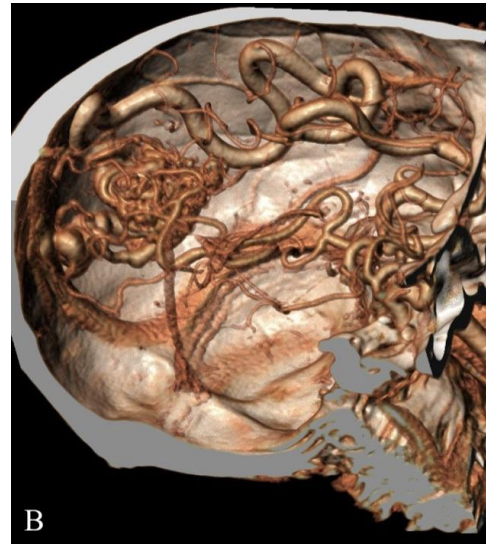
Head CT scan demonstrating intraparenchymal hemorrhage in the left parieto-occipital lobes with intraventricular bleeding in the ipsilateral lateral ventricle (a-b); the presence on multiple small calcifications and dilated vessels already raises the strong suspicion of the presence of a bAVM. CTA confirmed the presence of a large bAVM, main feeding vessels of which arise from the left MCA and from the ipsilateral posterior cerebral artery. The venous drainage is superficial, through a dilated vein reaching the transverse sinus as demonstrated by volume rendering reconstructions from CTA (b).
